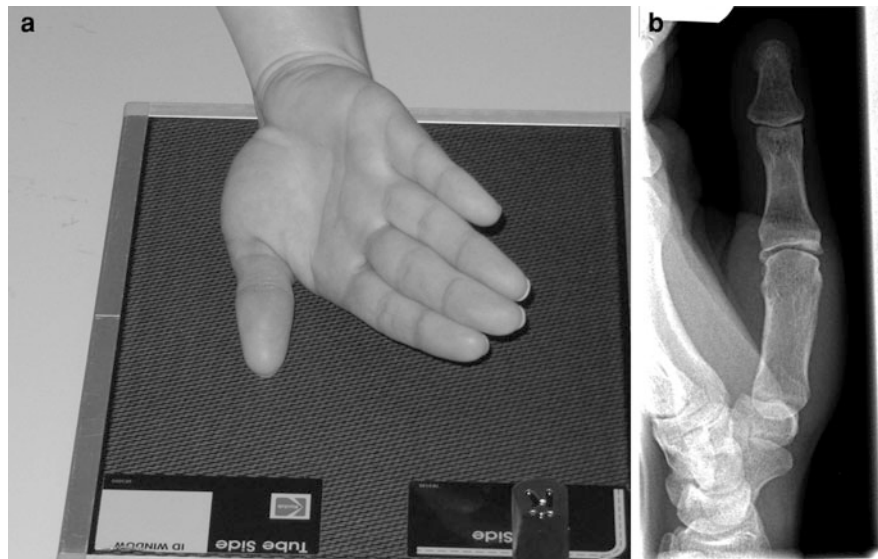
a Patient positioning for lateral of second and third fingers. b Patient positioning for lateral of fourth and fifth fingers. c Lateral radiograph of fingers
